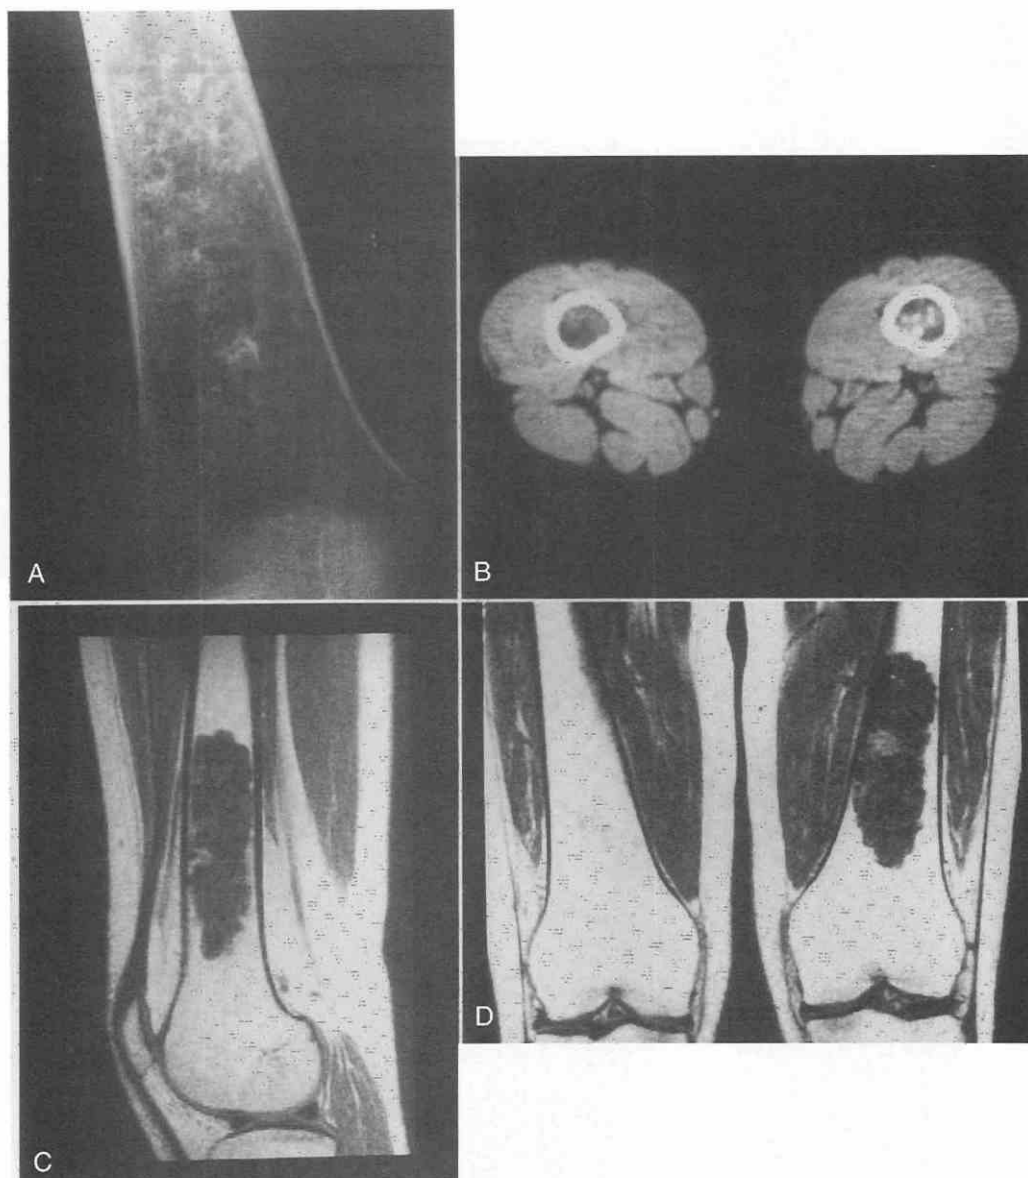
Primary grade I chondrosarcoma in a 36-year-old woman. *A*, Radiograph of the knee demonstrates a lesion with a cartilaginous matrix in the distal femur. *B*, CT scan shows the calcifications in the matrix of the lesion. *C* and *D*, Sagittal (*C*) and coronal (*D*) spin-echo images (TR = 500 msec, TE = 17 msec) demonstrate a lobulated lesion in the medullary cavity. The exact extension of the lesion is easily appreciated, but the matrix calcifications are poorly seen.
